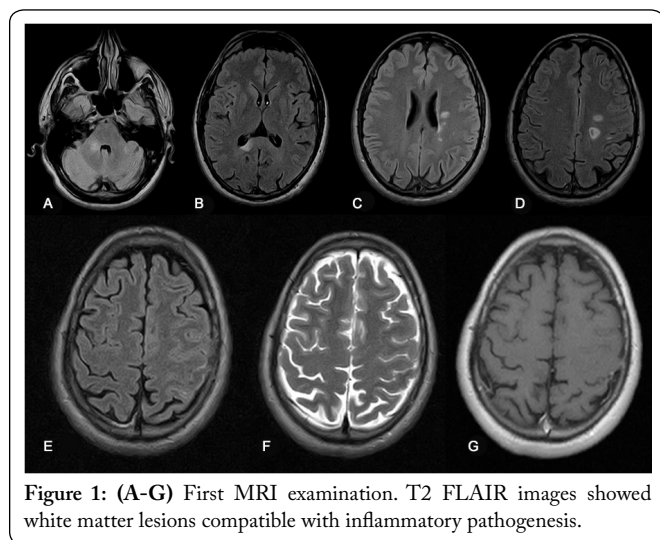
(A-G) First MRI examination. T2 FLAIR images showed white matter lesions compatible with inflammatory pathogenesis.
